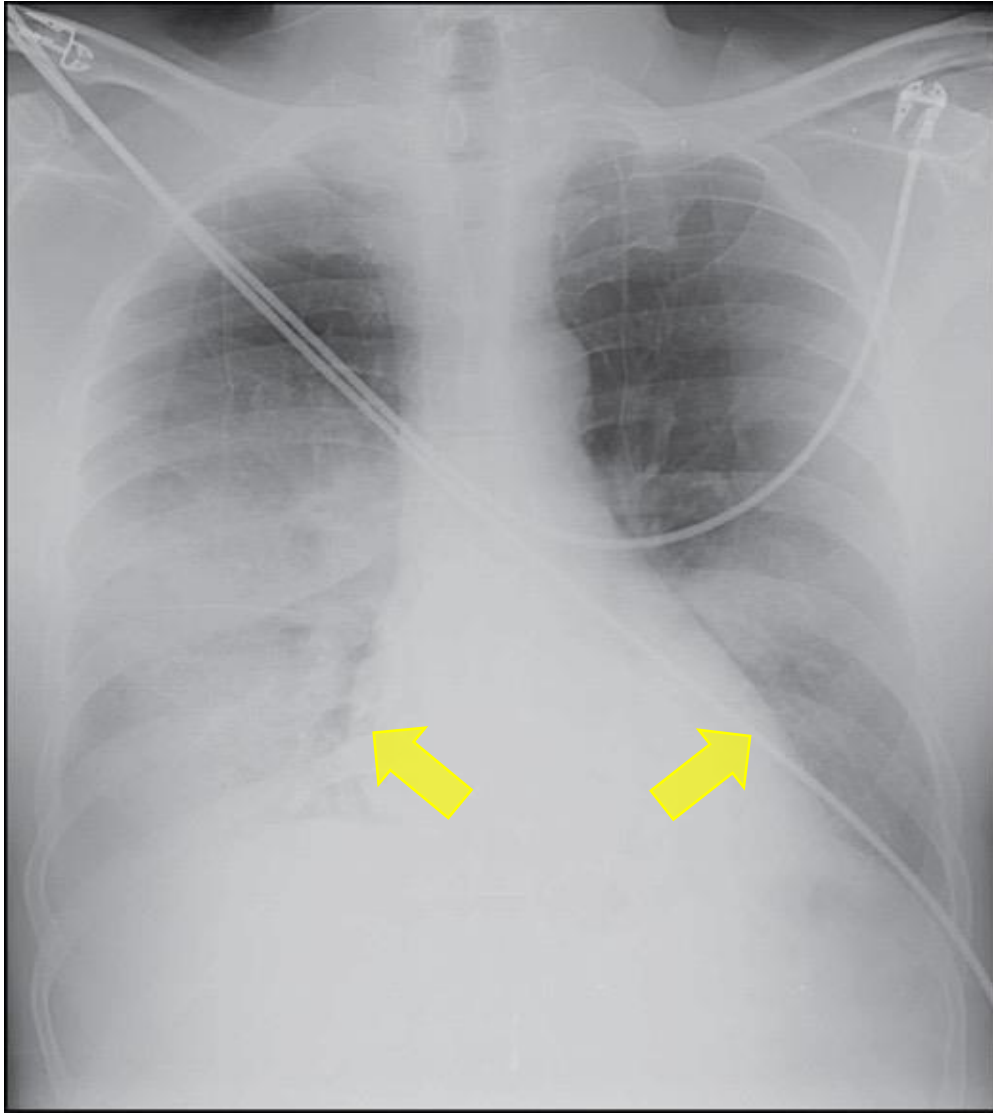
Chest Radiography of a Fatal Case of Influenza-Bacterial Co-infection.
